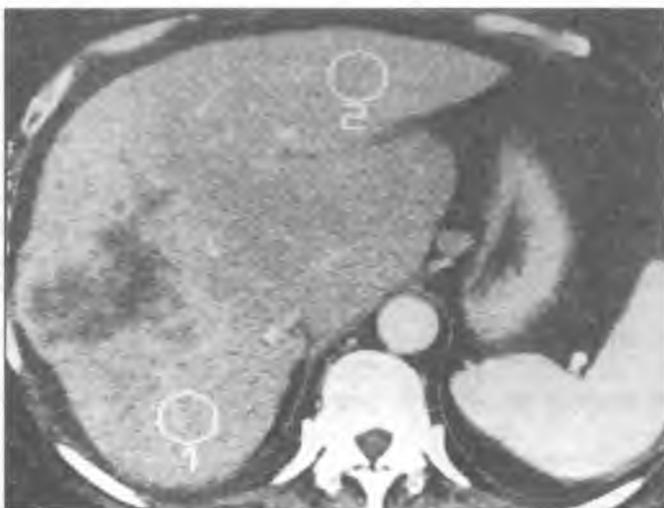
Dynamic CT scan of the patient with cirrhosis and peripheral enhancing foci of tumour (hepatoma).
